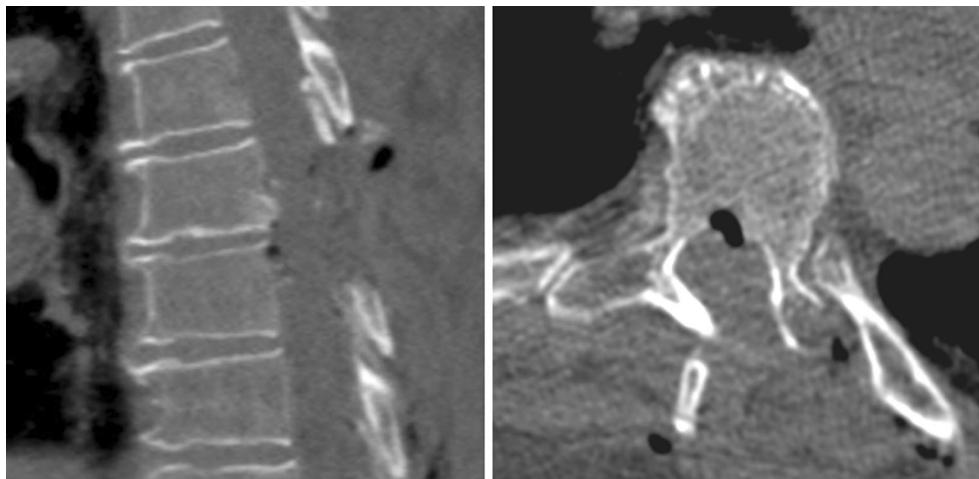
Case 2 postoperative CT scan showing complete resection of the disc herniation
